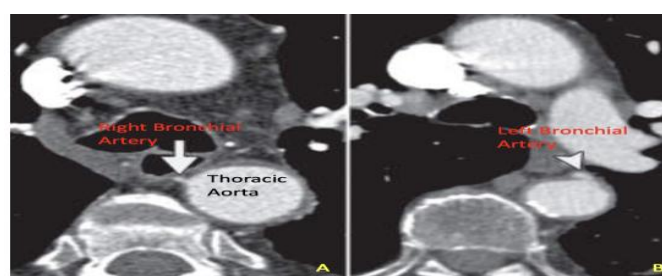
(A) Axial CT angiogram shows right bronchial artery (arrow) originating from the anteromedial thoracic aortic wall. (B) shows an orthotopic left bronchial artery (arrowhead) originating from the anterior thoracic aortic wall.
